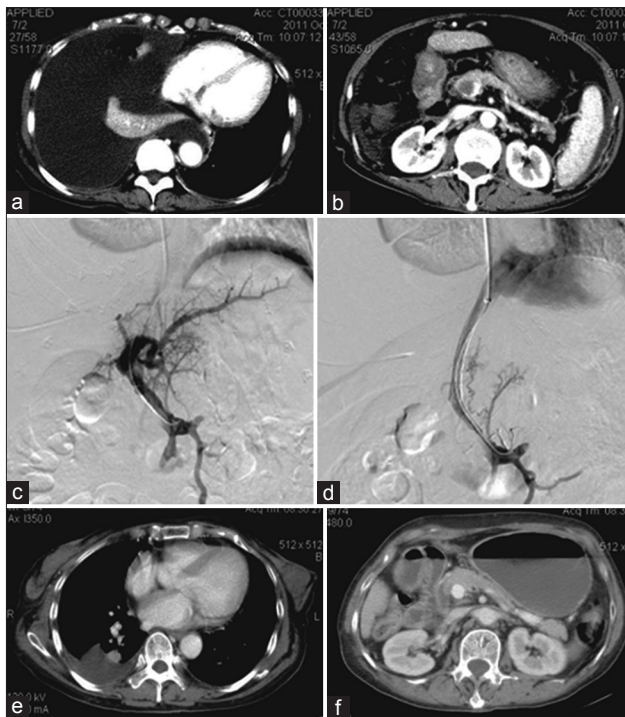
Preoperative contrast computed tomography demonstrated pleural fluid and thrombosis of the portal vein (a and b). (c) Before stent implantation, digital subtraction angiography showed that thrombus was observed in the main trunk and left branch of portal vein and the superior mesenteric vein. (d) A 10 mm × 50 mm covered stent was implanted. Follow-up computed tomography at the 4th month showed further regression of hydrothorax and portal vein thrombosis (e and f).
